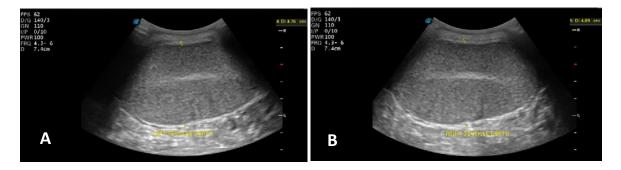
Ultrasonographic images of left (A) and right testis (B)
